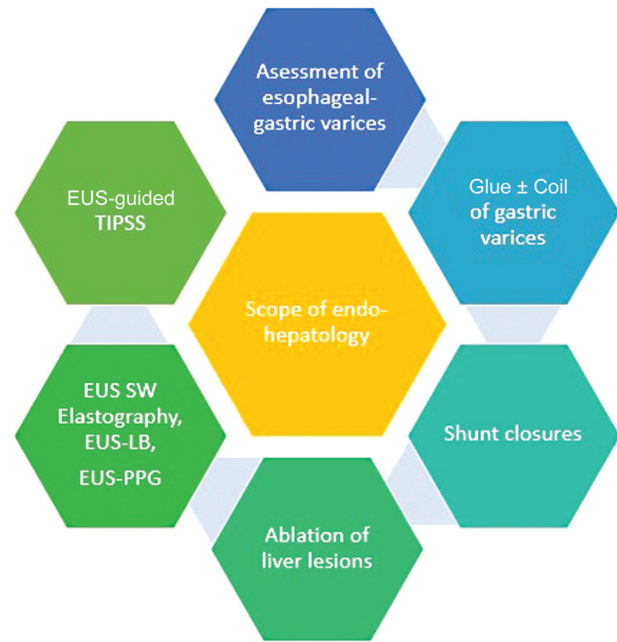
Scope of endo-hepatology. EUS, endoscopic ultrasound; LB, liver biopsy; PPG, portal pressure gradient; SW, shear wave; TIPSS, transjugular intrahepatic portosystemic shunting.
